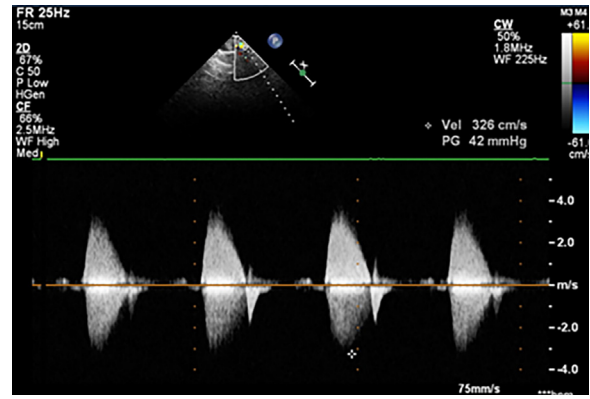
Echocardiogram showing coarctation of aorta distal to left subclavian with peak gradient of 42 mm Hg.
